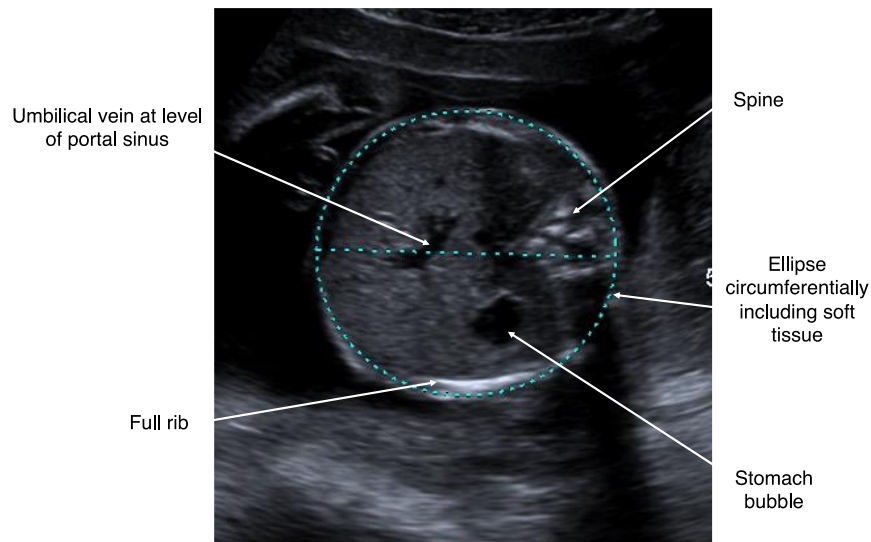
Ultrasound view required for the measurement of abdominal circumference (AC) >14 weeks gestation.
